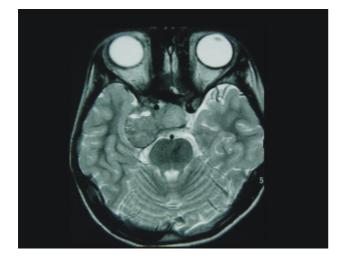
T2-weighted MR image showing Grade II pituitary tumor with bilateral cavernous sinus invasion. Both cavernous carotid arteries are encased without luminal compromise. B. T2-weighted axial image shows the bilateral involvement of the cavernous sinus.
